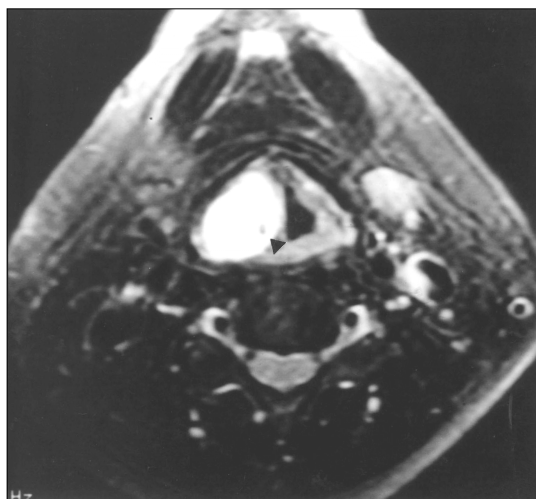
MRI finding. T2-weighted axial MRI shows a homogeneous high signal intensity mass (arrow head).
